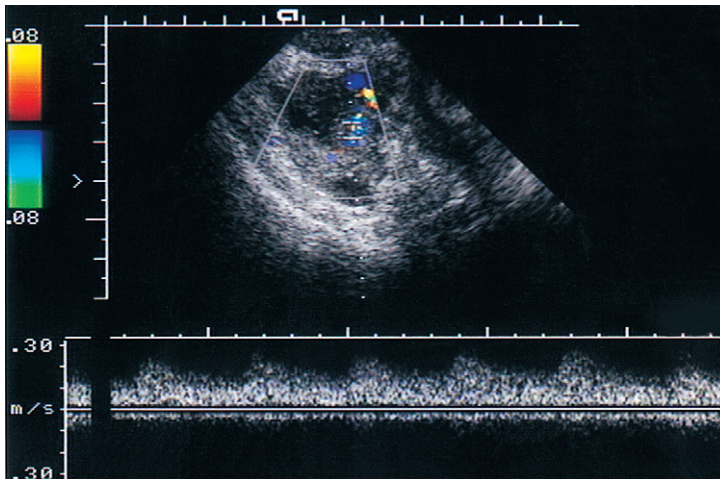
Solid ovarian tumour with colour flow Doppler at the margin and spectral Doppler demonstrating low resistance.
